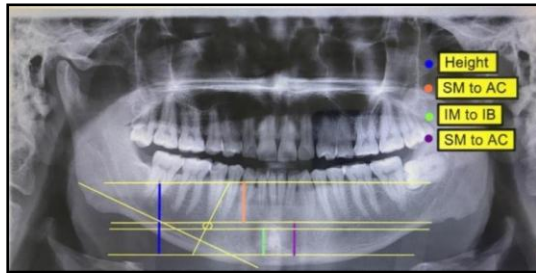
Measurements in orthopantomogram radiograph for gender determination.
